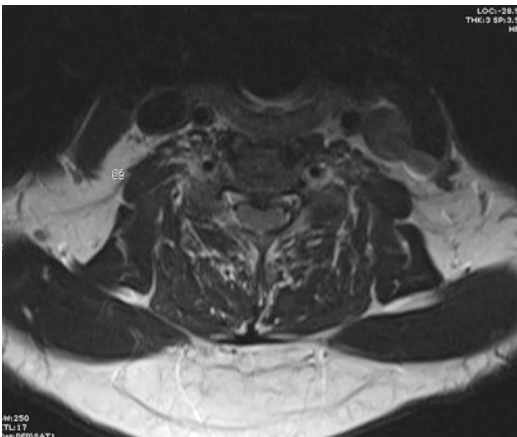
Axial MRI demonstrating severe spinal canal stenosis at the C5–C6 level
